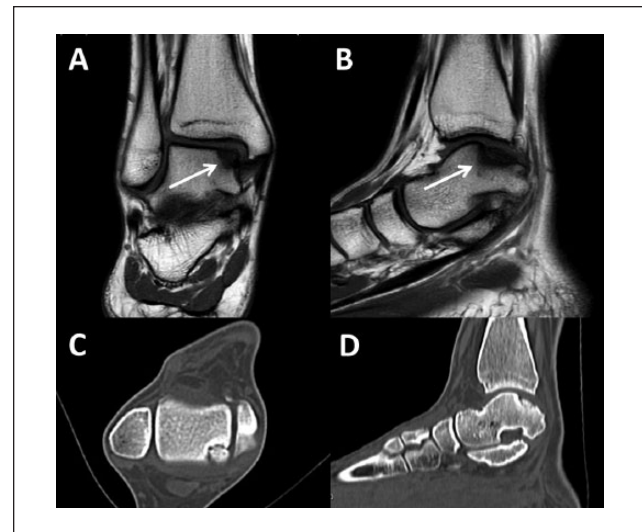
MRI and CT images of OLT in a 16-year-old girl. (A) Coronal and (B) sagittal MR images showing a displaced OLT (arrows). (C and D) CT images showing the extent of the lesion in the posteromedial corner of the talar dome. CT, computed tomography; MRI, magnetic resonance imaging; OLT, osteochondral lesion of the talus.
